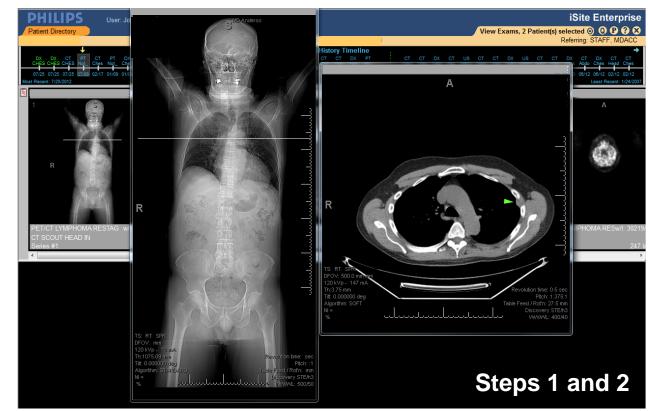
Use of Scout Line Mode to determine center of PPS region from most recent CT study.
